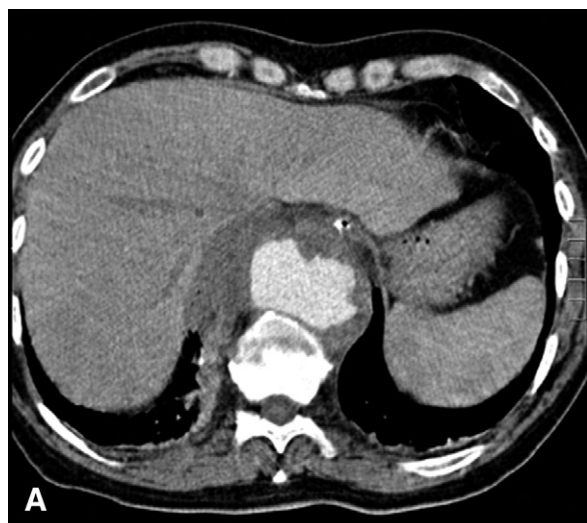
A and B, Preoperative computed tomography angiography of a patient with a ruptured mycotic aneurysm in the descending thoracic aorta.
